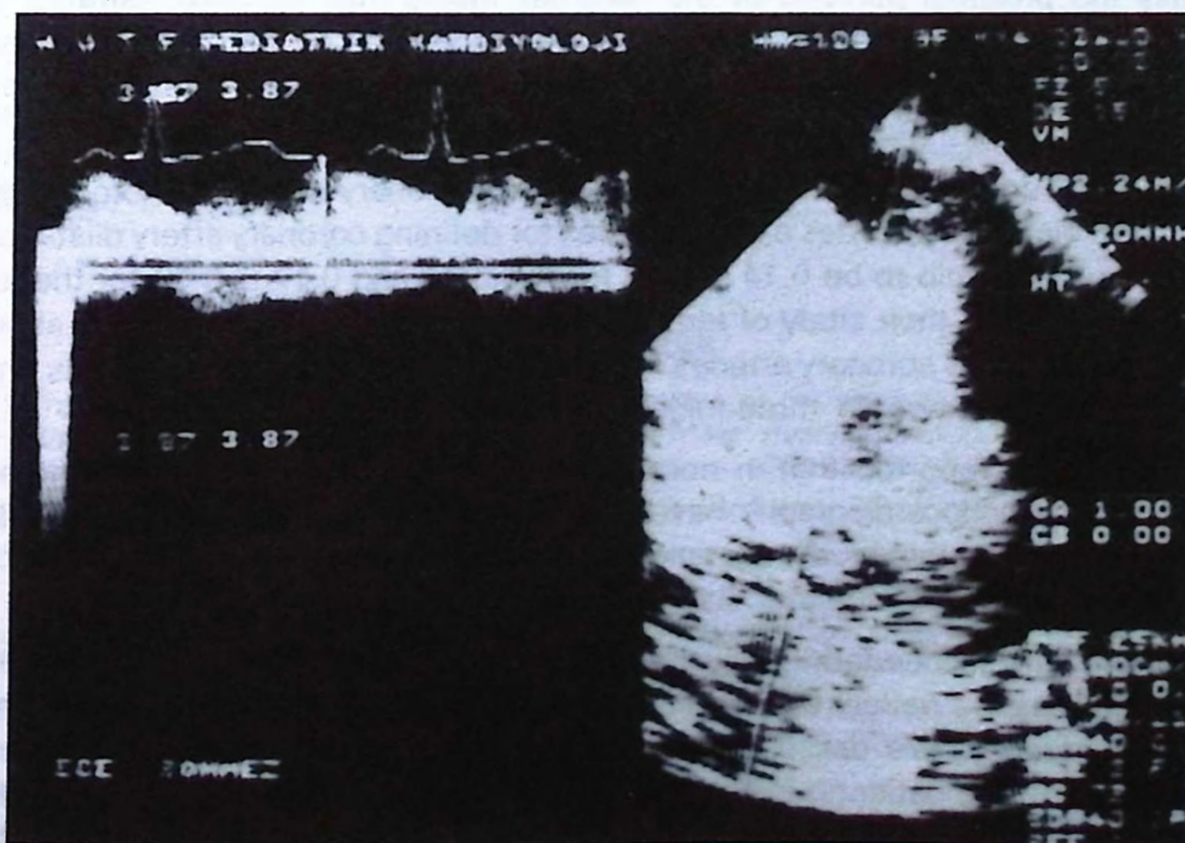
Continuous disturbed flow with diastolic accentuation (left) demonstrated near apex by Doppler echocardiography.
